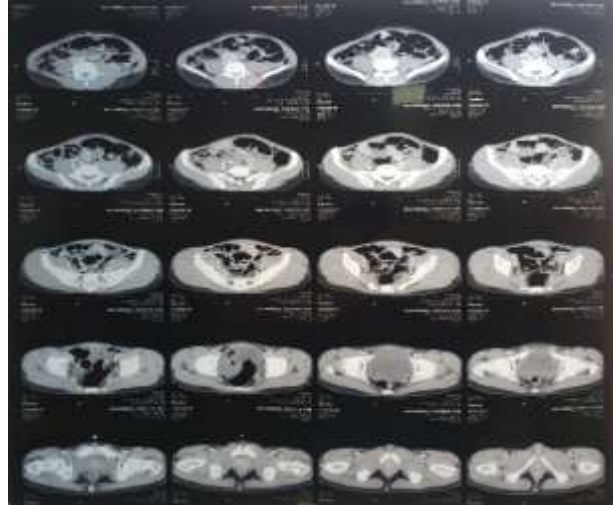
CT Scan Abdomen showing intraperitoneal adhesions encapsulating small gut.
